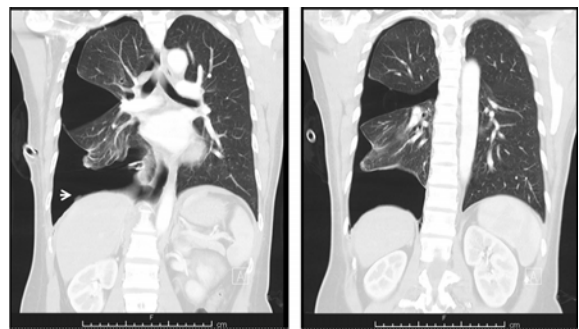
CT-chest: Coronal view evidence with arrow sign showing a right diaphragmatic nodule. Visceral pleura are seen. Right upper lung bleb was seen between right upper and middle lung.
